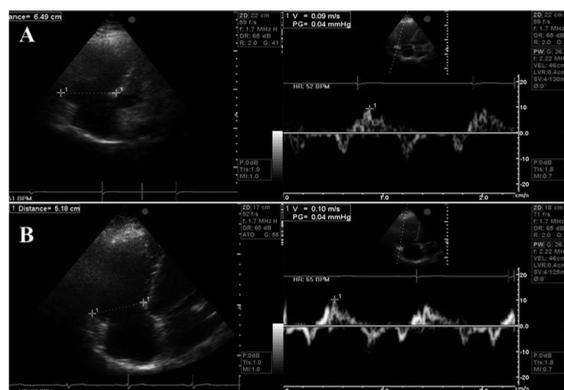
Echocardiographic study in a patient with preoperative RV dysfunction (A): RV dysfunction remains unchanged after PV replacement with reduced, nevertheless, RV dilatation (B).
